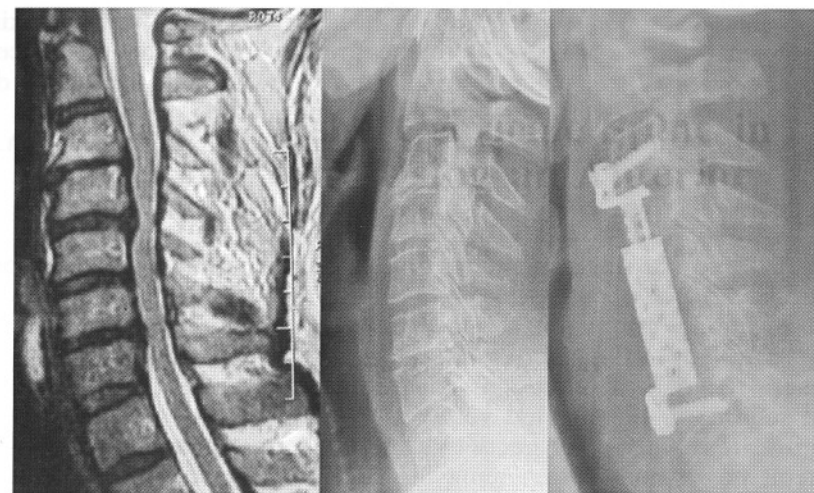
multisegmental cervical stenosis with myelopathy, left: preoperative MRI, middle: preoperative x-ray, right: postoperative x-ray, ADD<sup>plus</sup>-Implant
